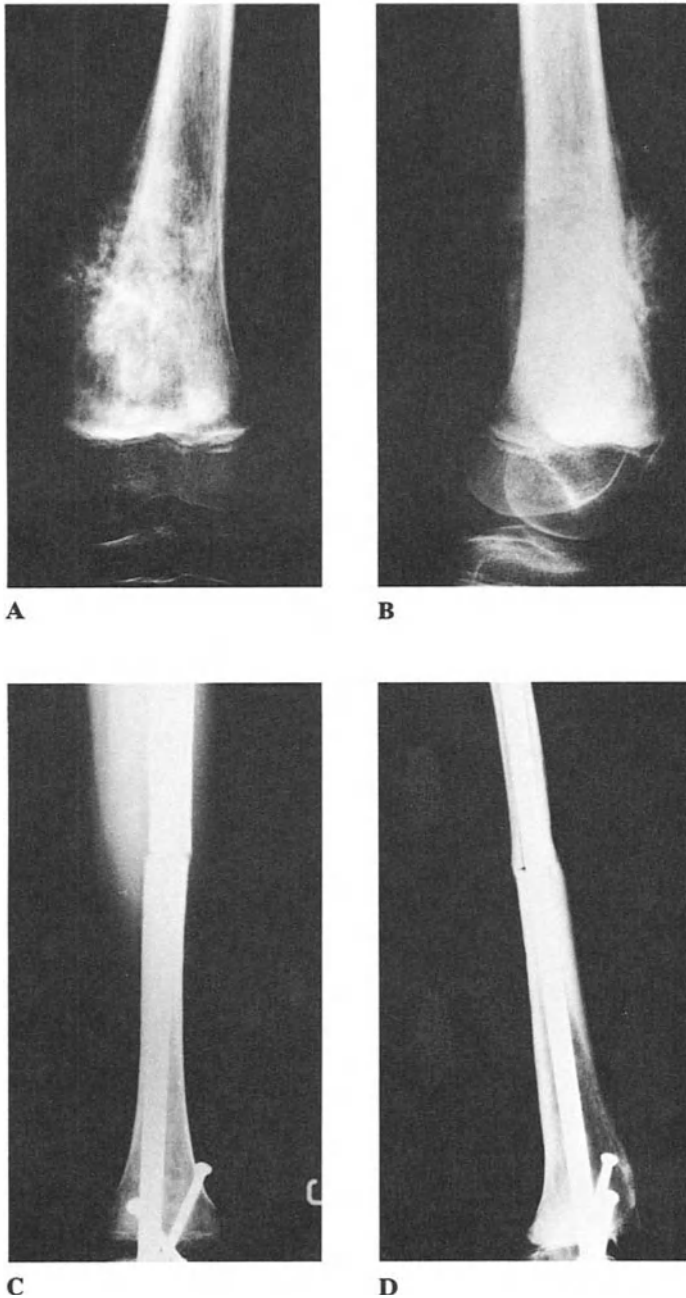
Osteoblastic osteosarcoma in a 10-year-old female. A, B: Standard x-rays. C, D: Wide resection and reconstruction with an intercalary allograft arthrodesis: x-ray control at 9 months showing a good fusion of the graft.
